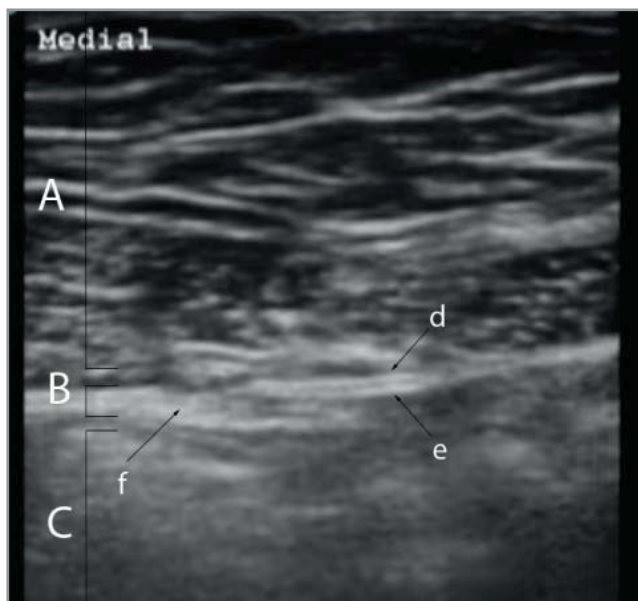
Sonographic changes of fascia and peritoneum complex and adhesions attachment (the transverse section in middle epigastric region): A — abdominal wall structures; B — fascia and peritoneum complex; C — viscera; arrow d — the transverse abdominal fascia; e — the parietal peritoneum; f — FPC hypotrophy in place of adhesion attachment
